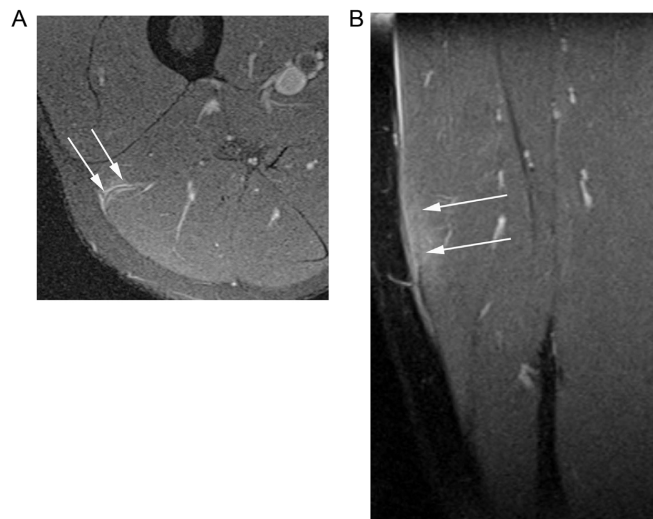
When signal changes (oedema or tears) were centered next to the peripheral fascia, the myofascial location was used for grading. (A) Axial PDw FS MRI shows mild oedema surrounding the peripheral fascia of the long head of biceps femoris, with normal morphology and signal of the adjacent fascia (arrows). (B) Coronal PDw FS MRI shows, in another similar injury, the adjacent fascia exhibits thickening and signal changes (arrows), without disruption. Using the Chan acute muscle strain injury classification, this could represent myofascial (2b) or myofascial/perifascial (2c) muscular injuries and we considered both injuries as grade 1 in terms of severity. Regarding the location, the injury was considered as grade 2Bb in “A” (muscle – middle – myofascial) whereas in “B” it was considered as grade 2Bc (muscle – middle – myofascial/perifascial). Using the British Athletics muscle injury classification, this represents myofascial (a) injuries, where both injuries were graded as 1a. Using the modified Peetrons grading system, both injuries were considered as grade 1.
